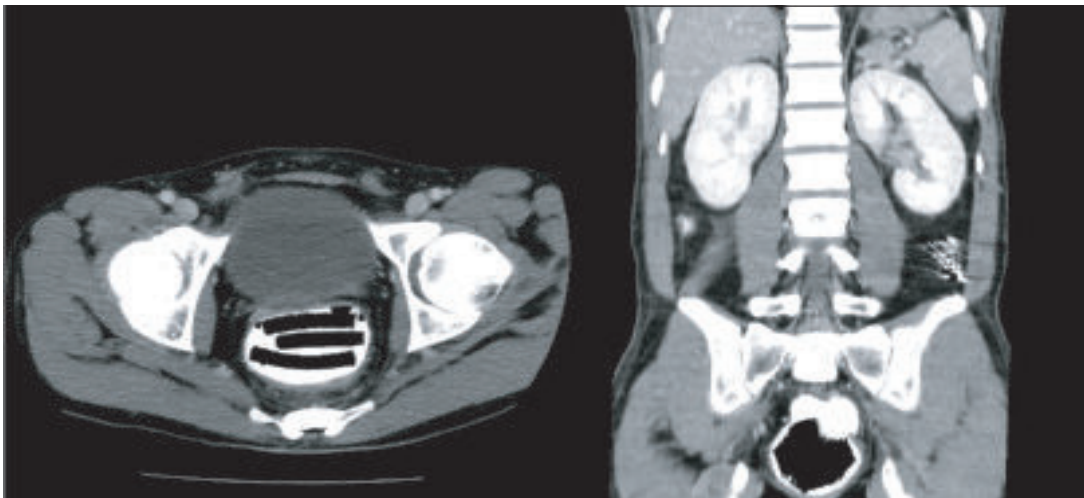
Abdominal CT showed the foreign bodies to move in the rectal ampulla.
